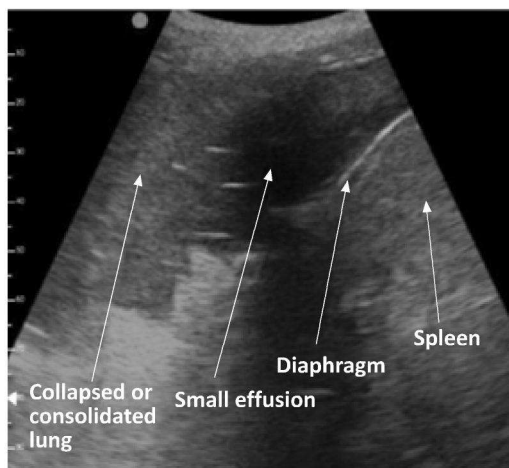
Large area of collapsed or consolidated lung. The lung should not be seen on ultrasound as air does not allow passage of sound waves. If there is dense consolidation or atelectasis, the lung will appear similar to the liver in appearance.
